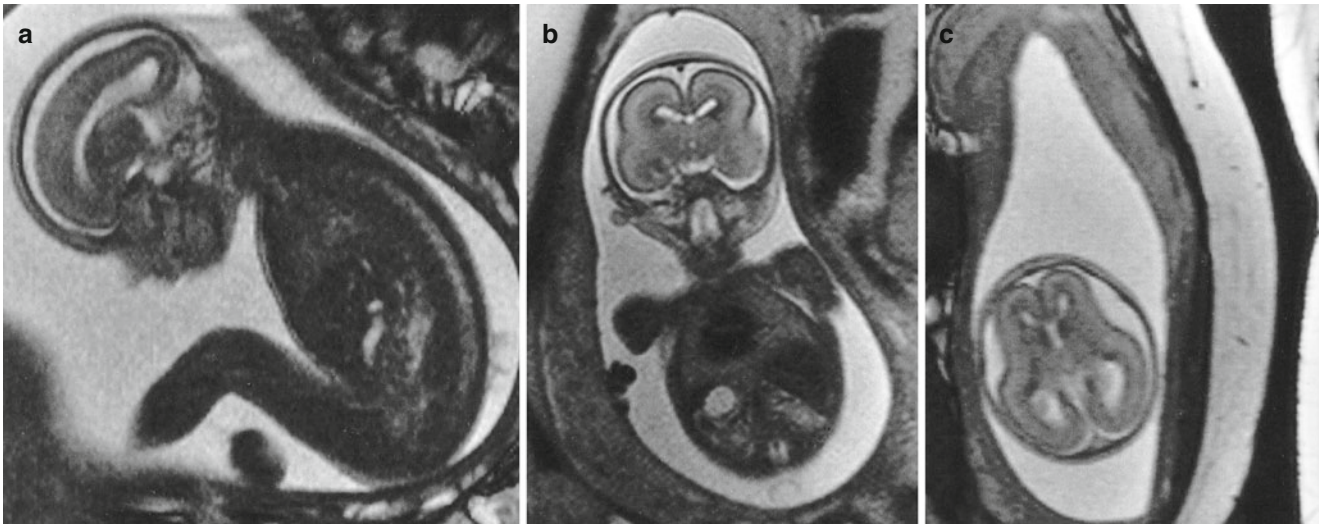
Fetal T2-weighted MRI taken at the 20th week of development: (a) sagittal section; (b) frontal (or coronal) section; and (c) horizontal (or axial) section. There is a smooth cerebral surface
